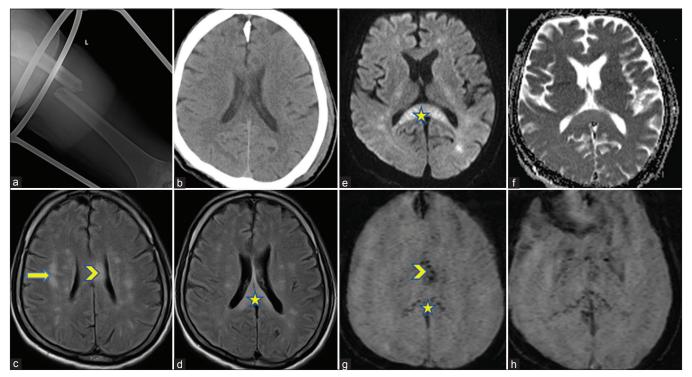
(a) Left femur radiograph showing displaced fracture of shaft with limb in Thomas splint. (b) Admission CT Brain axial image shows essentially normal neuroparenchyma. (c and d) Day-14 post fixation axial FLAIR images show hyperintense areas within bilateral cerebral white matter (arrow), body (arrow head) and in the splenium of corpus callosum. (e) DWI and (f) ADC maps show facilitated diffusion within the corpus callosum. (g and h) mIP SWI images showing obvious punctate hypointense foci in the body (arrowhead) and splenium (star) of corpus callosum, and a few in the subcortical region (h).
